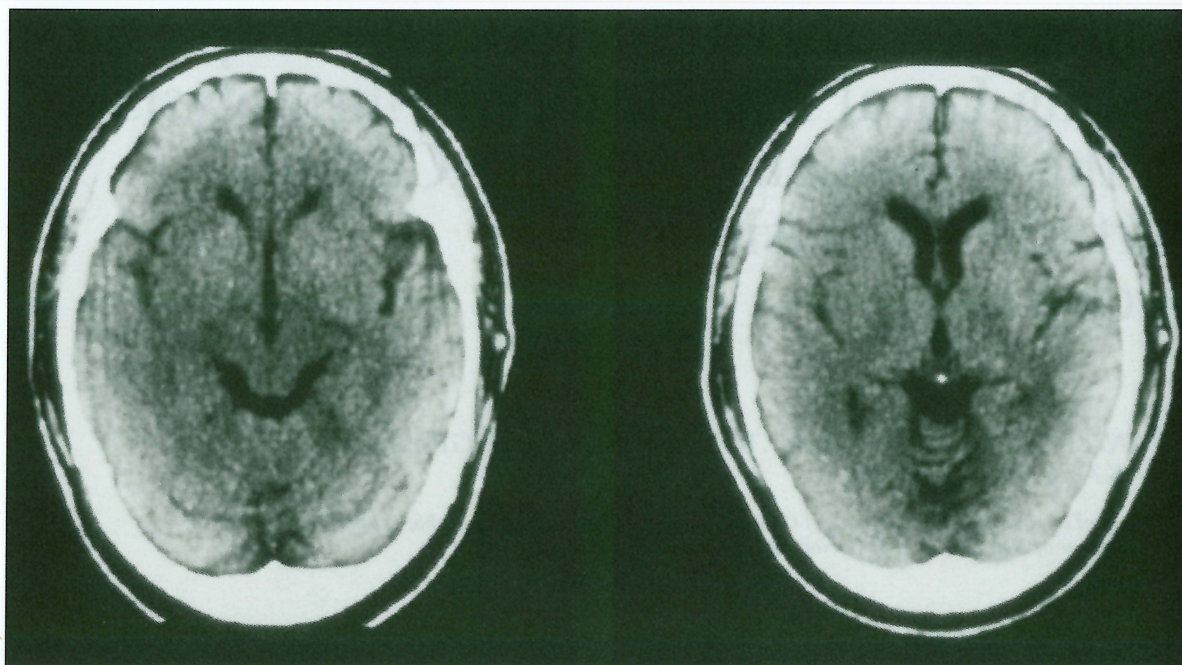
Computed tomography on admission, showing no low-density area.
